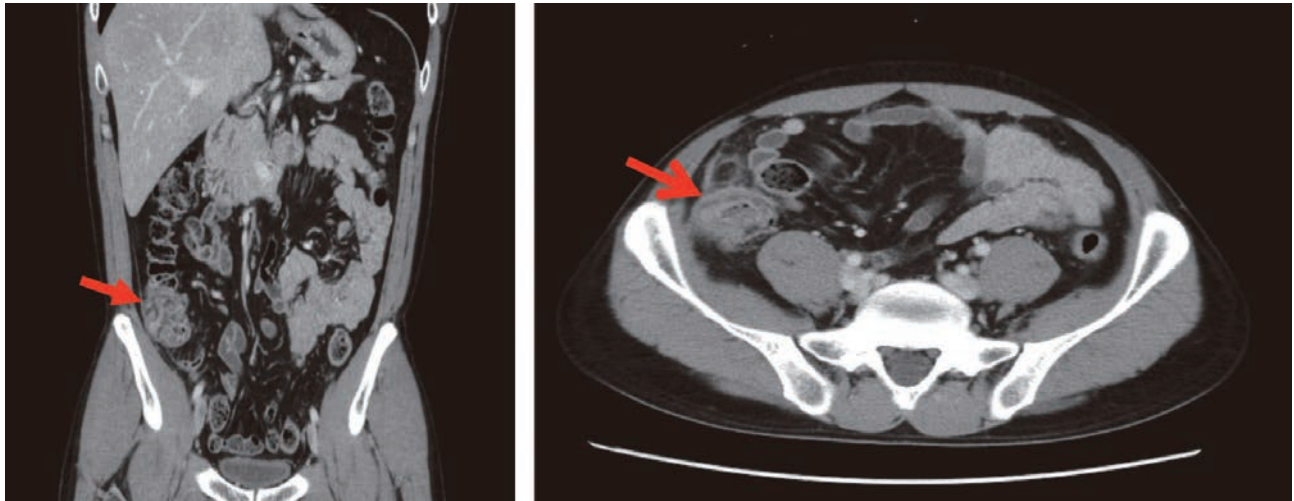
Computed tomograms (coronal and transverse views) show a pericolic enhanced fat-mass-like lesion (arrows) and stranding at the ileocecum.
